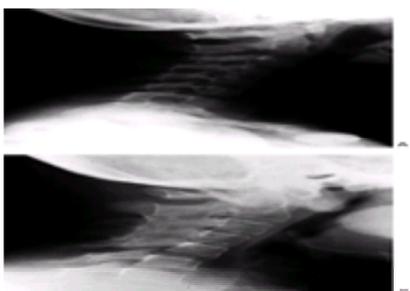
The cervical spine in a child with polyarticular JIA. A: At 6 years of age, there are no radiographic abnormalities. B: At 21 years of age, there is ankylosis of C2–C5.
